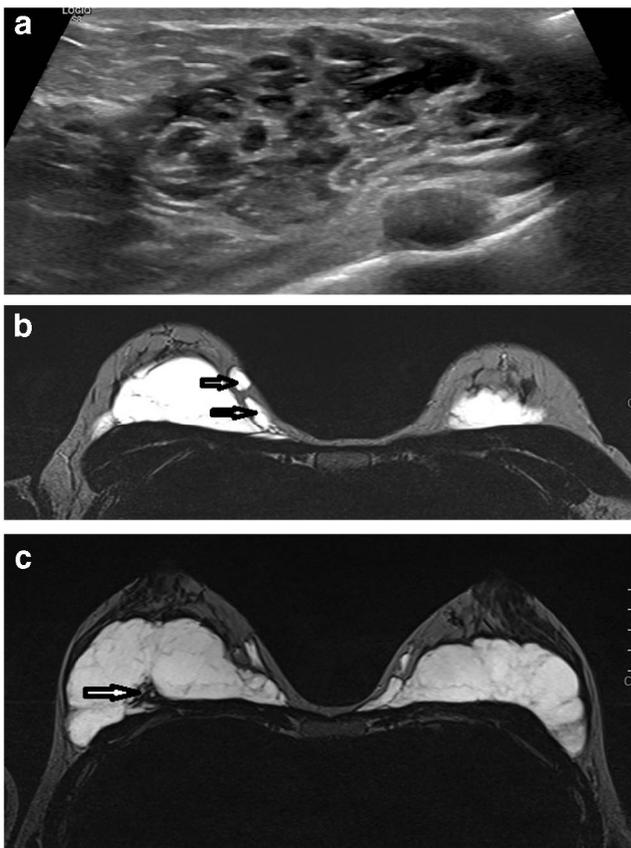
32-year-old female. a An ill-defined complex cystic structure is seen on US in the retroglandular area of the right breast. b Axial fat sat T2-W TRIM MRI reveals hyperintense and heterogenous loculated areas (arrows) with migration of the Aquafilling material into the subcutaneous fat tissue in the middle-inner quadrant of the right breast and c among pectoral muscle fibers (arrow)
